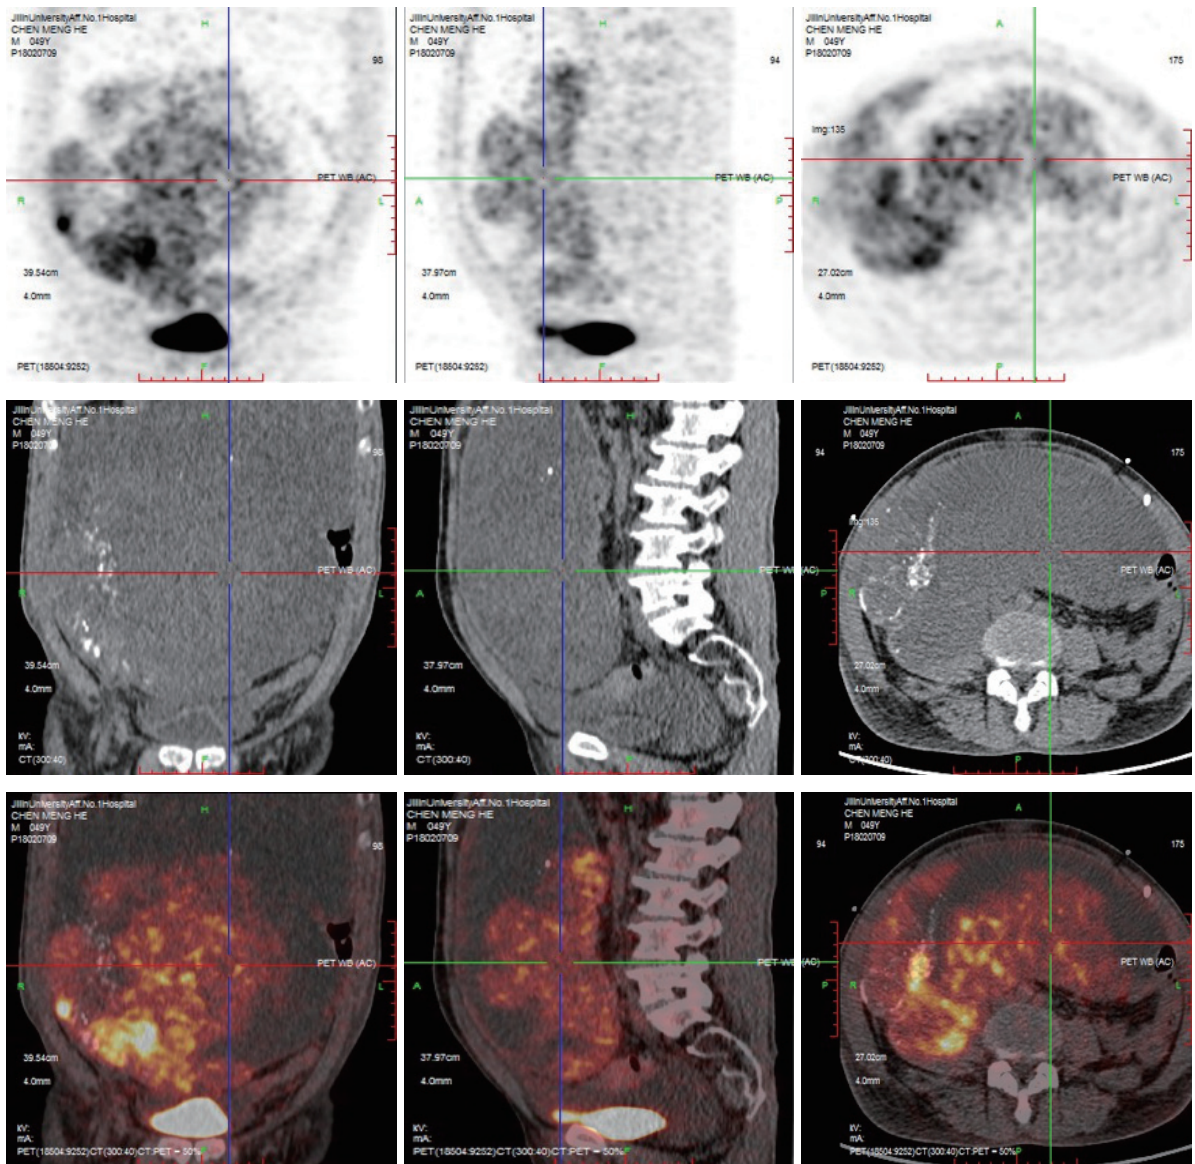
PET-CT 显示中下腹部巨大混杂密度团块, 放射性高摄取病灶范围 20.2 cm × 19.3 cm × 20.7 cm, SUV 值 4.8~9.6
